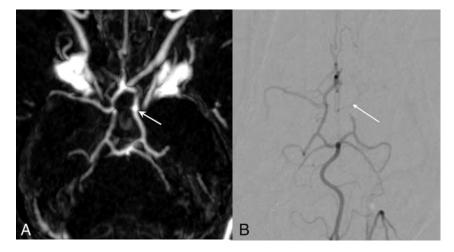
A*, C-arm CT arterial phase 3D reconstruction show a proximal middle cerebral artery occlusion (*white arrow*). *B*, Comparison with 2D DSA selective angiogram performed 4 hours earlier also shows a proximal MCA occlusion.
